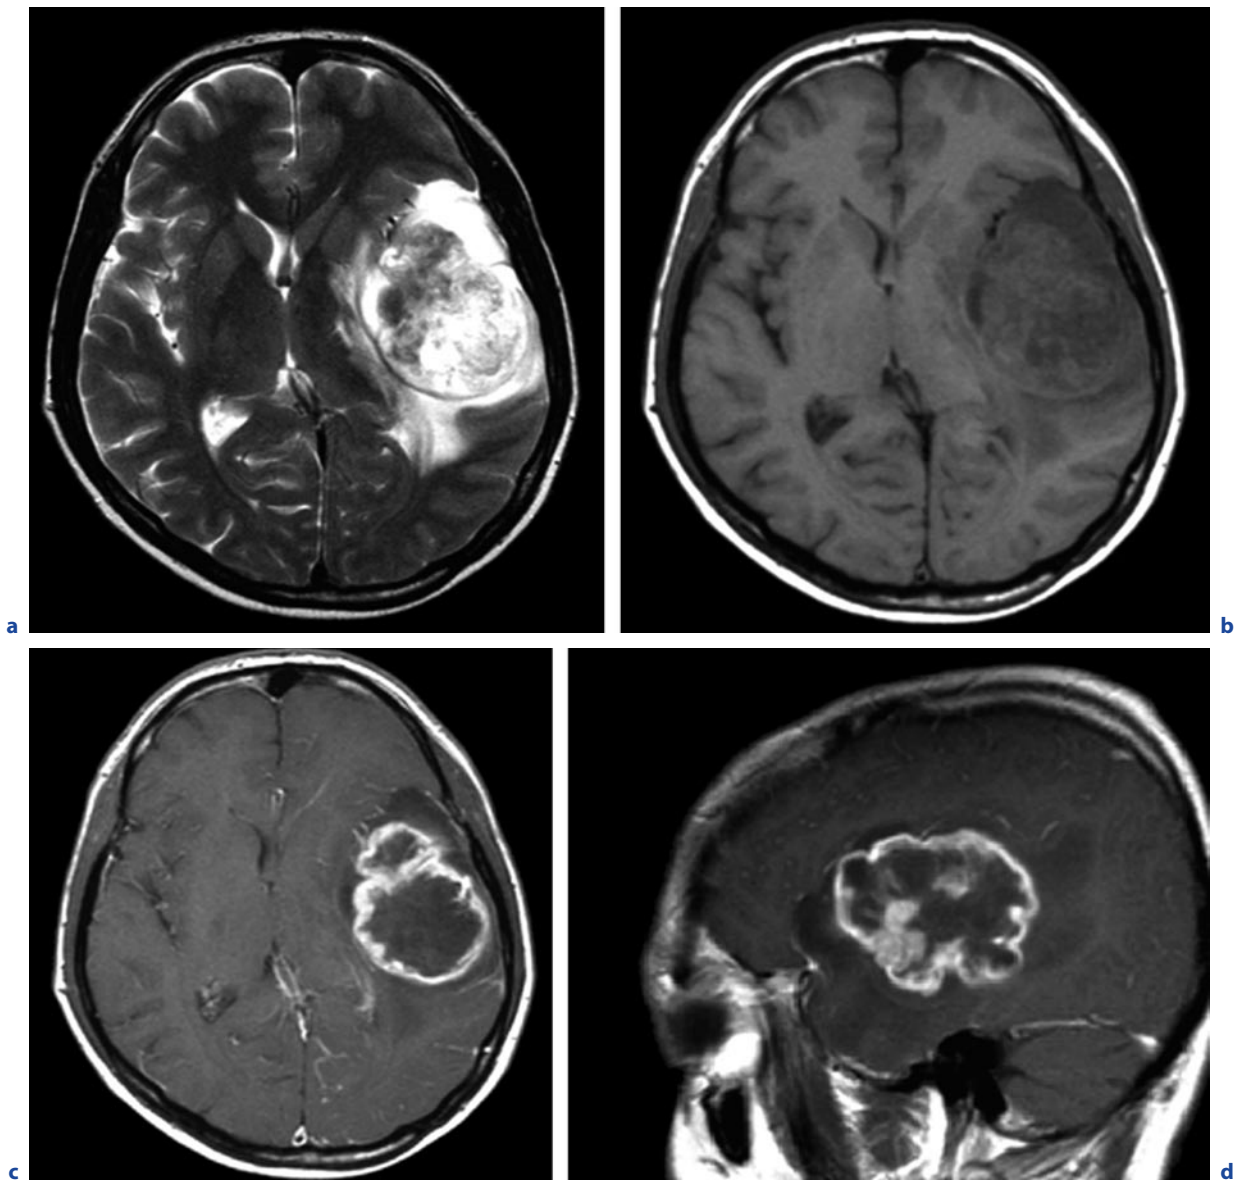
Glioblastoma multiforme as differential diagnosis of solitary brain abscess in a 54-year-old man, rapid progressive headache, aphasia, hemiparesis. a Axial T2-weighted image. b Axial T1-weighted image before contrast administration. c Axial T1-weighted image after contrast administration. d Sagittal T1-weighted image after contrast administration.
